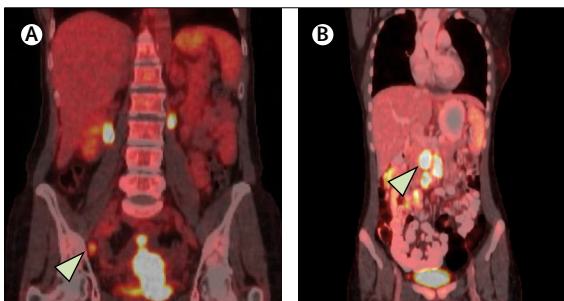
PET/CT of patient with cervical cancer with metastases in pelvic and para-aortic lymph nodes
